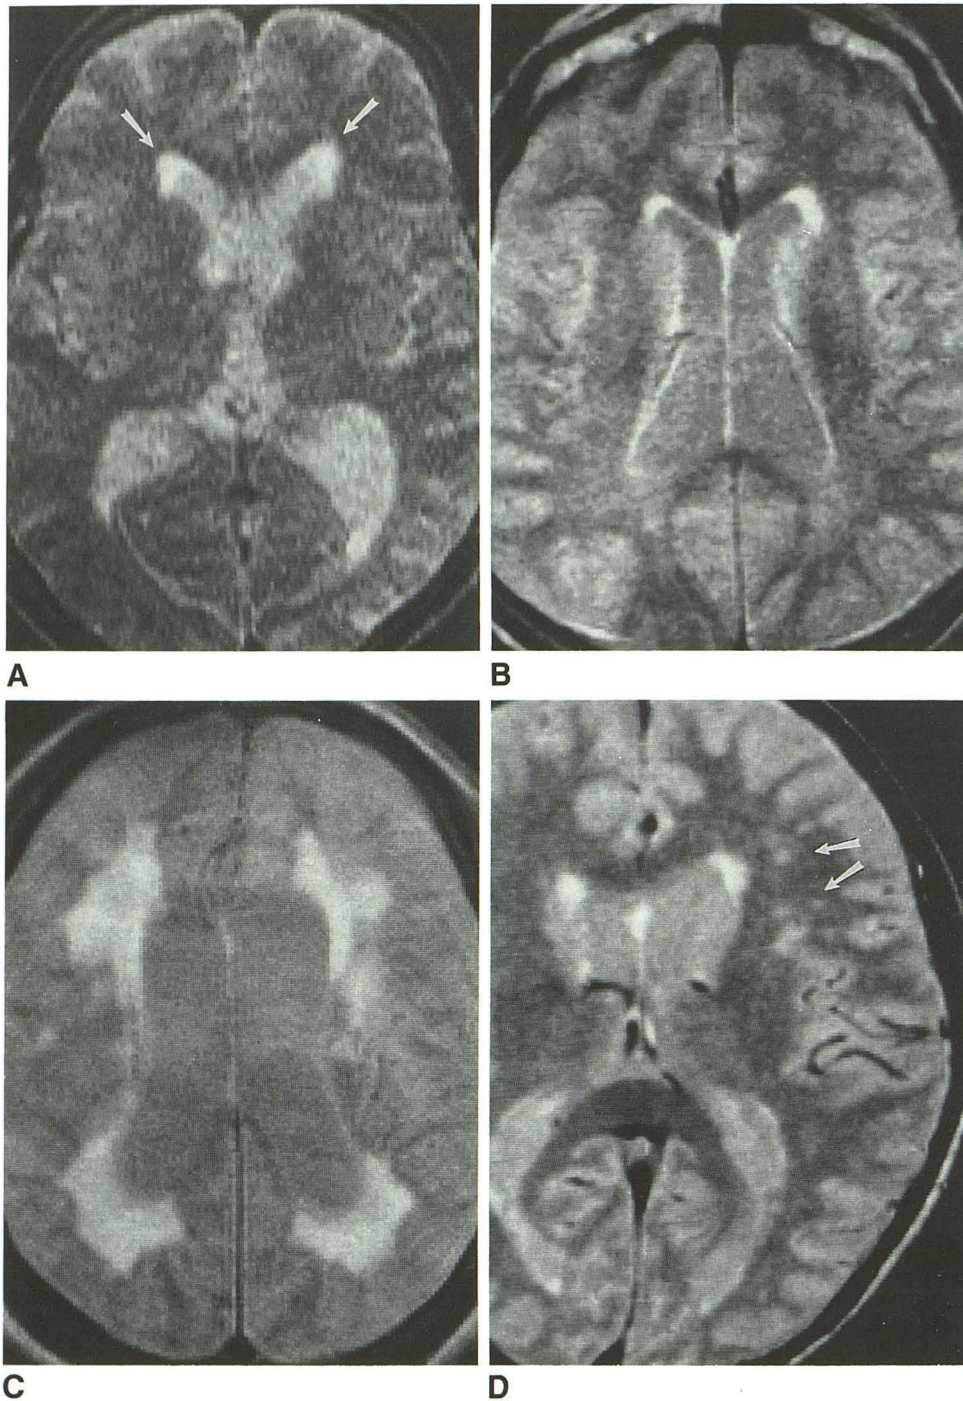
Examples of periventricular (A–C) and subcortical white-matter (D) high-intensity lesions detected by T2-weighted MR.
